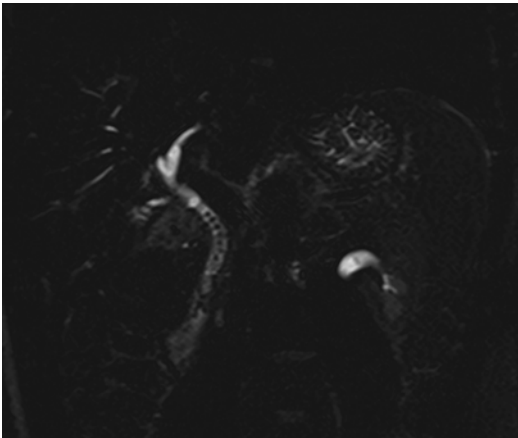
MRCP of a patient presenting with elevated liver function tests. Coronal T2-weighted images demonstrated choledocholithiasis and mild ductal dilatation
